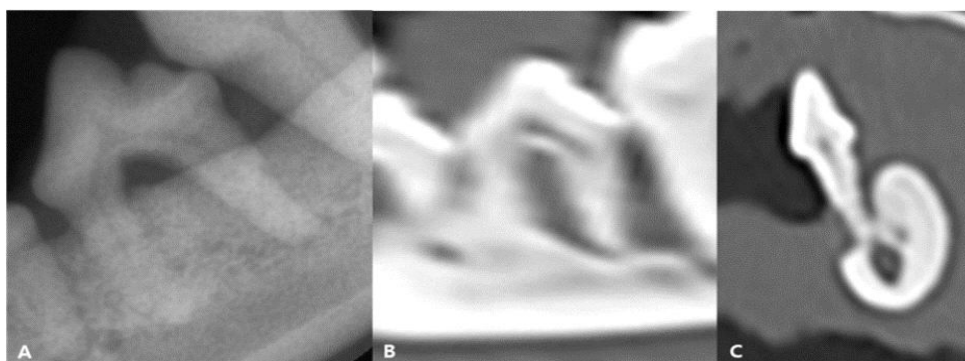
Image of third premolar in a 13-year-old Maltese. Horizontal alveolar bone loss was detected in DTR but vertical bone loss could be underestimated in this image (A). However, severe alveolar bone loss is remarkable in buccal aspect in sagittal (B) and transverse (C) CT MPR (multiplanar reconstruction) images.
